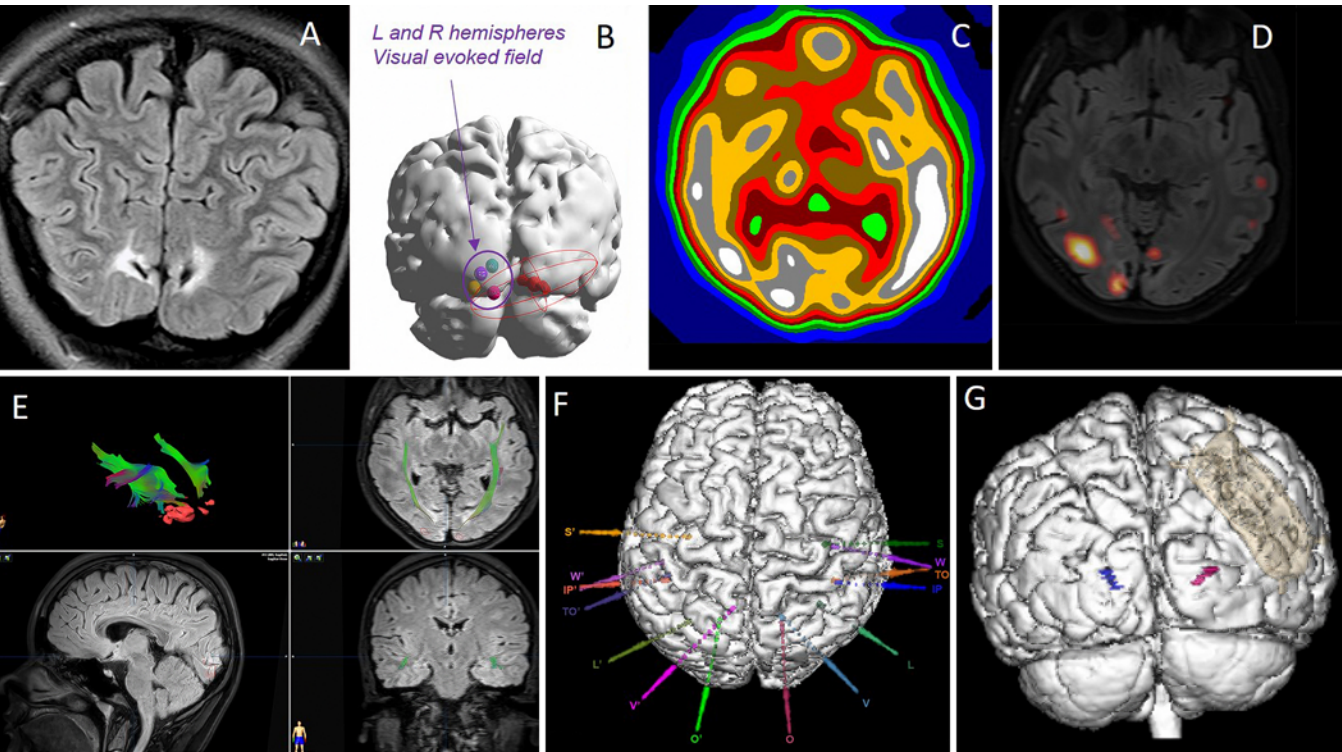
Patient 3. This patient had intractable seizures after severe hypoglycemic insult secondary to hyperinsulinism from islet cell adenoma. A: Coronal FLAIR sequence MR image demonstrating bioccipital insults. B: Magnetoencephalography source localization with equivalent current dipole showing sources localizing in the right inferior occipital head region. The electrographic seizure localized at onset to the right inferior occipital lobe with subsequent spread to the left inferior occipital lobe. Right and left hemifield visual evoked fields both demonstrated localization to the left occipital lobe. C and D: Ictal SPECT scans. Isotope was administered 24 seconds after onset of ictal EEG changes from an electroclinical seizure originating from the right occipital region. E: Functional MR images of visual fields with representation of bioccipital lesions (red) and visual tractography (green). F: Three-dimensional CT reconstruction of bilateral SEEG. Ten seizures were recorded during monitoring, 4 with ictal onset localized to the left O' electrode and 6 localizing to the right O electrode. G: Three-dimensional CT reconstruction of RNS and final bioccipital lead placement. Figure is available in color online only.
